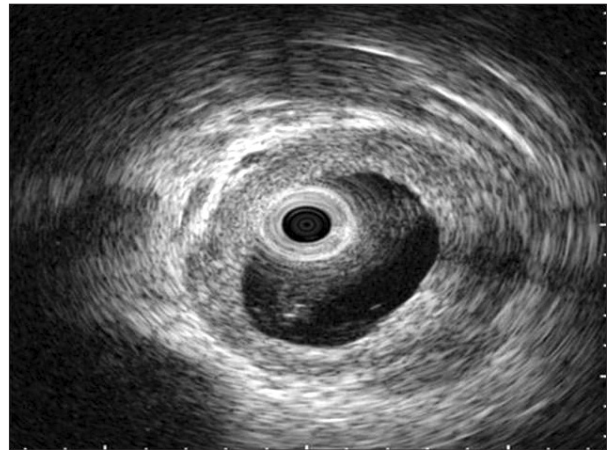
Intraductal ultrasonography shows wall thickness with smooth outer margins in the bile ducts without stenosis in immunoglobulin G4-related sclerosing cholangitis patients.
